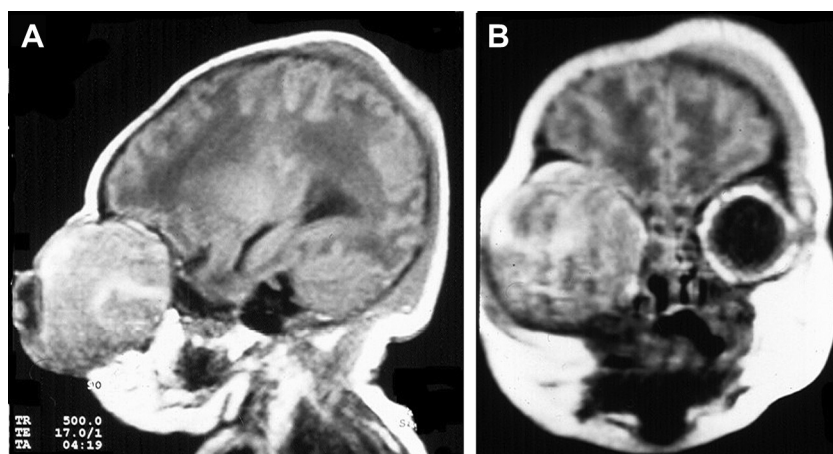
Sagittal (A) and coronal (B) T1-weighted magnetic resonance image, demonstrating a right retrobulbar mass causing profound proptosis in a 1-day-old neonate. The mass occupies nearly the entire right orbit and deforms the ipsilateral globe. Note the irregular post-contrast enhancement pattern originally thought to be consistent with cavernous hemangioma.
